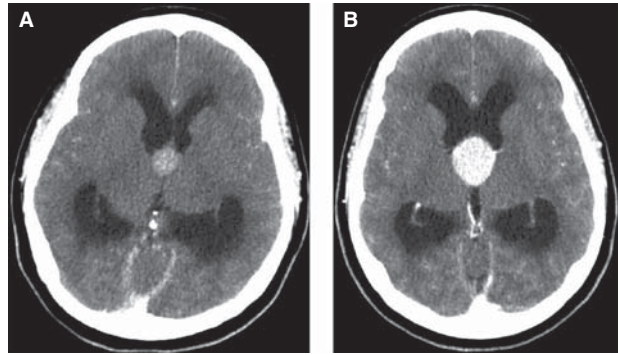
A: CT scan of Sister A, carried out when she went to the emergency room. There is a contrast-enhancing lesion in the third ventricle in the region of foramen Monroi. Also, there is a pronounced obstructive hydrocephalus with dilatation of the lateral ventricles. 201 × 201 mm (72 × 72 DPI). B: CT scan of Sister B, carried out when we got to know that she was under investigation for severe headache attacks. As in her twin sister, there is a contrast-enhancing lesion in the third ventricle in the region of foramen Monroi. There is a pronounced obstructive hydrocephalus with dilatation of the lateral ventricles as well. 201 × 201 mm (72 × 72 DPI).
